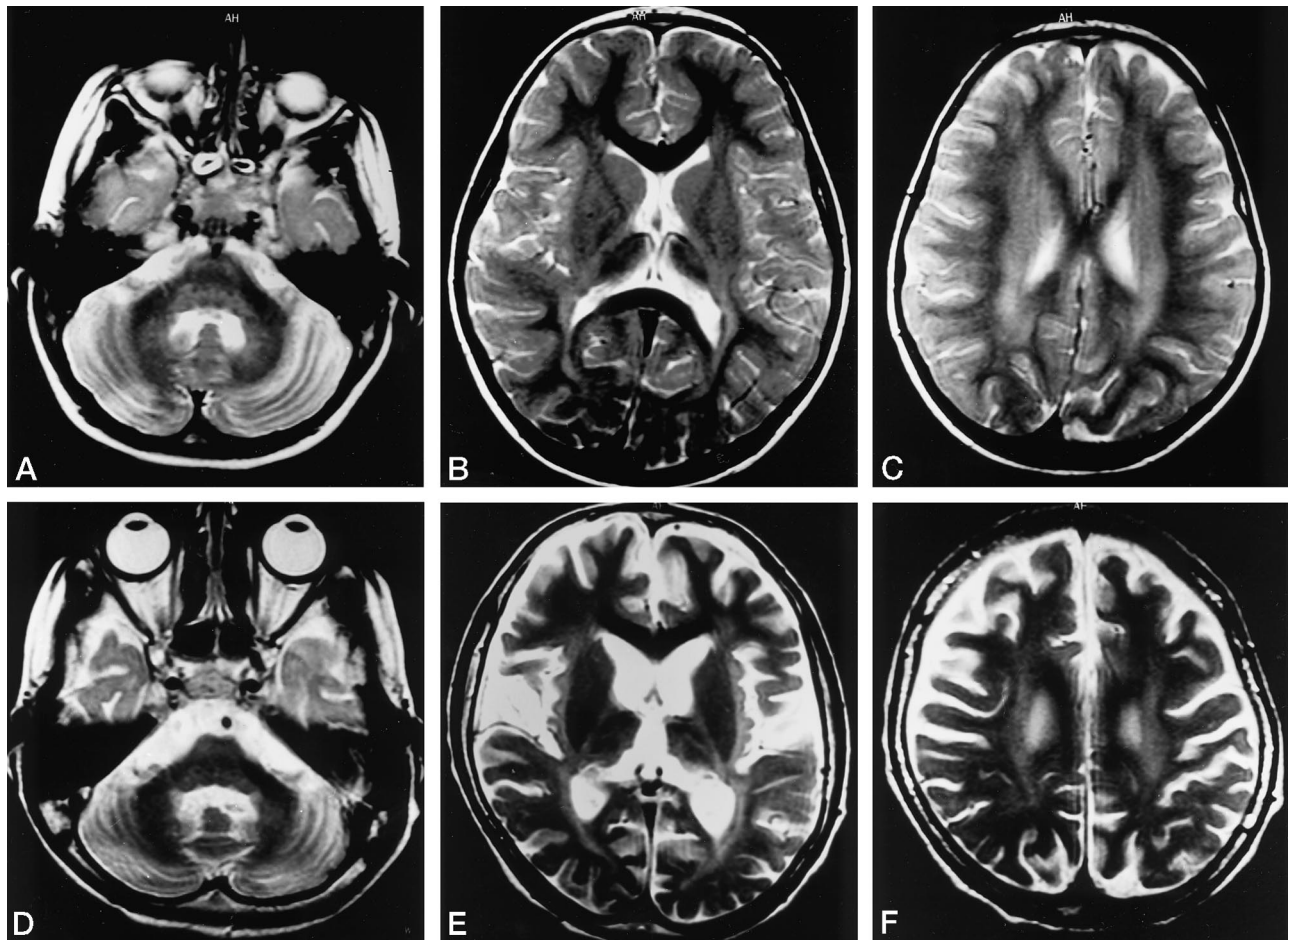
Axial T2-weighted images (3000/90/2) in the early (patient 2, A–C) and progressed (patient 3, D–F) stages of late infantile NCL. The progressing cerebellar atrophy results in enlargement of the cerebellopontine cistern and the fourth ventricle (A and D). There is a hyperintense periventricular band, an increased signal in the internal capsule, and a hypointense thalamus on images through the basal ganglia (B and E). The gray matter becomes atrophic in combination with a hyperintense white matter as the disease progresses (C and F).
